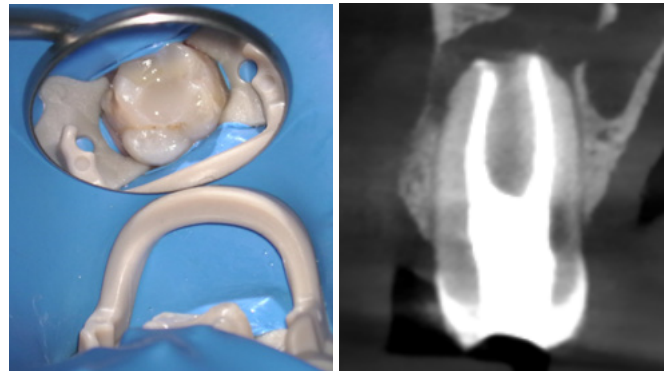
SimpliShade™ Bulk Fill was used to complete the procedure. Postoperative radiographs and CBCT confirmed that the obturation was dense and properly positioned at the apex of both canals.
